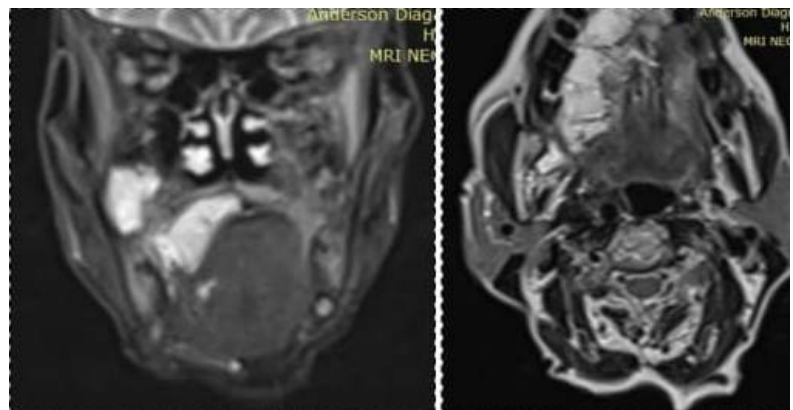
Magnetic resonance imaging (MRI) of the tongue lesion demonstrating its extent and internal characteristics.
